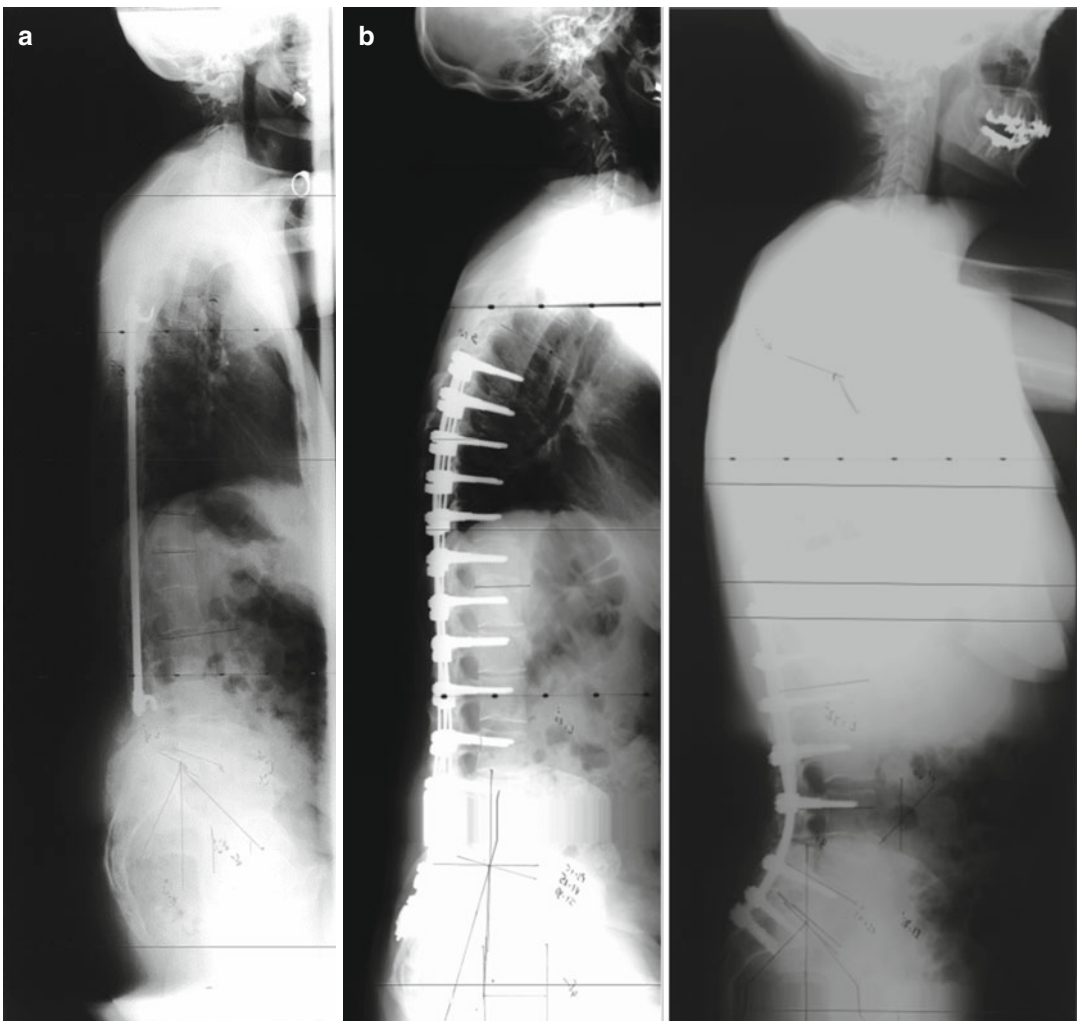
(a) Full-length radiography demonstrating a flatback posture post a Harrington procedure. (b) Full-length radiography demonstrating a flatback posture following a multi-segmental scoliosis procedure Pr and post-op
